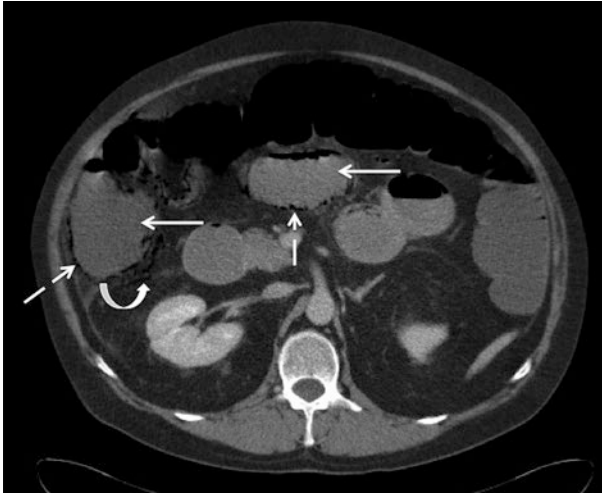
A 63-year-old man presents with severe generalized abdominal pain. Contrast-enhanced (portal venous phase) CT abdomen/pelvis demonstrates fluid-filled small and large bowel (solid arrows) with air lying dependently in the small and large bowel wall—pneumatosis intestinalis/coli (dashed arrows) and in pericolic veins (curved arrow). CT also showed an occlusion of the superior mesenteric artery (not shown)
